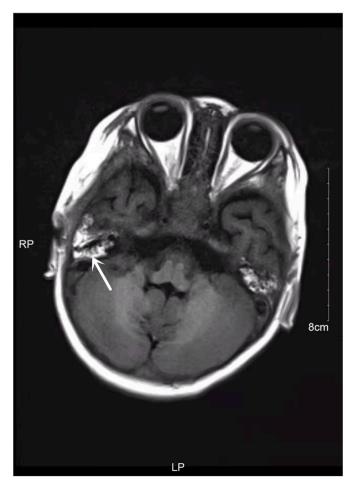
Magnetic resonance imaging of the patient after the injury. The arrow refers to the focus.
